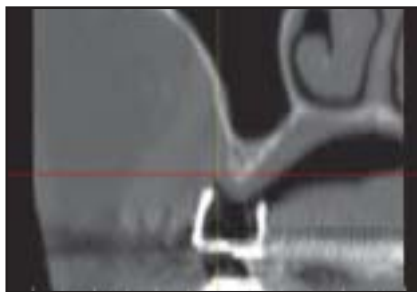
Cross-sectional CT view of the first molar position using SimPlant software. This first-generation scanning appliance demonstrates the optimal final tooth position in space. Disuse atrophy and residual ridge resorption are apparent along with sinus pneumatization.
